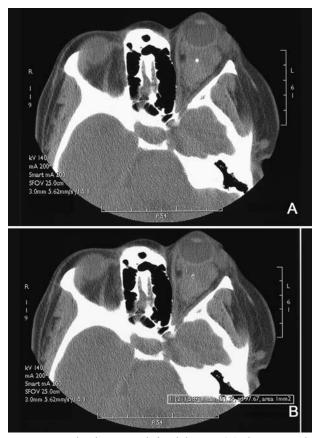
Orbital mass with focal density. (B) The CT number, shown as 451.29, is consistent with calcification, which is evidence of a phlebolith in a lymphangioma.
